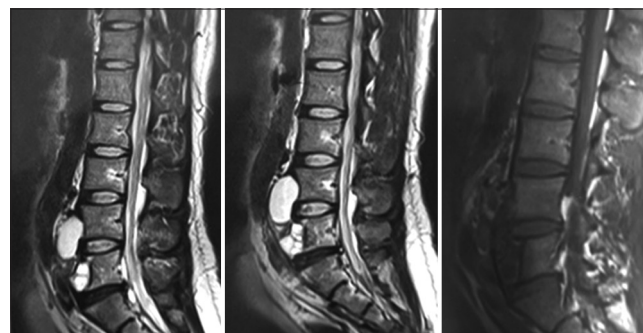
MRI findings of 2018
